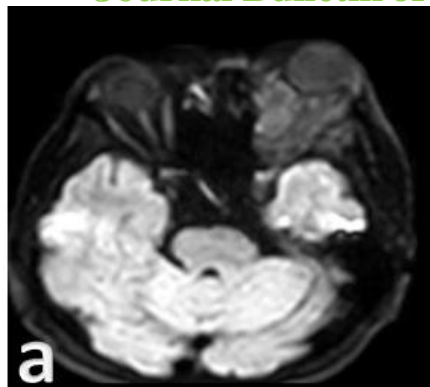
(a& b): Diffusion MRI displayed low intense SI on DWI and high intense SI on ADC (Free diffusion). ADC ratio measures $1.9 \times 10^{-3} \text{mm}^2/\text{s}$.
